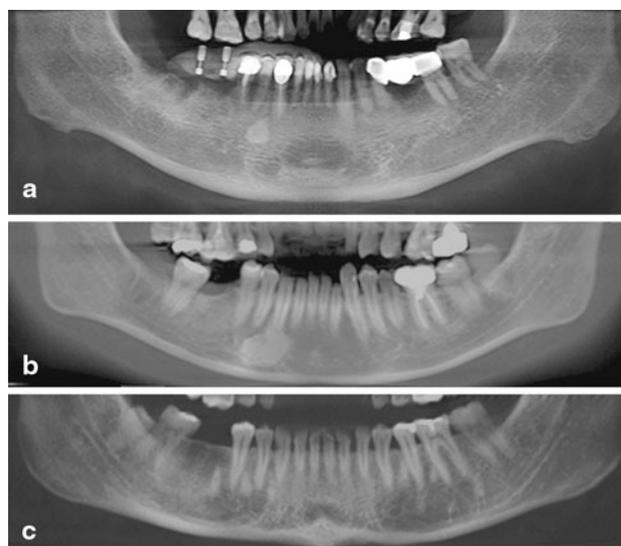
Panoramic view reconstructed from CBCT data to classify the different shapes of osteosclerotic lesions as circular (a), oval (b), or irregular (c)
